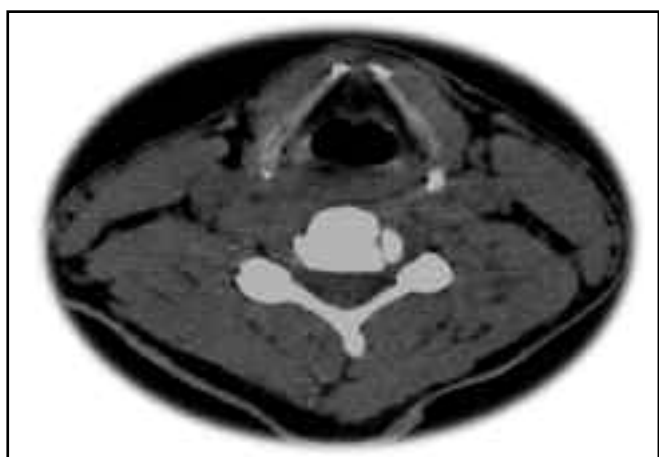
CT scan at rest.
